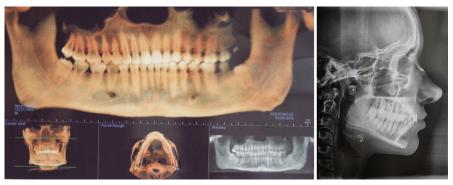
Panorex X-rays and PA and Lateral Cephalogram of Jaw as a part of preoperative work up.
